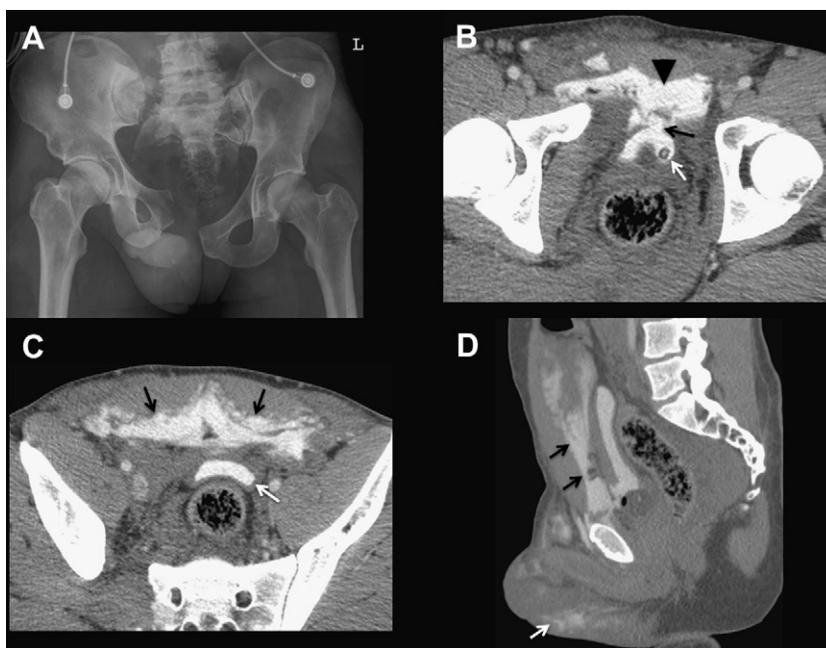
Extraperitoneal bladder rupture. (A) Frontal pelvic portable radiograph from a trauma series demonstrates a displaced vertical shear fracture with elevation of the right hemipelvis and marked diastasis at the pubic symphysis. (B) Axial CT cystogram image demonstrates extravasation of contrast from the anterior base of the bladder (*black arrow*). Contrast extends into the prevesicular space (*black arrowhead*). A Foley catheter is identified in the bladder lumen (*white arrow*). (C) Axial CT cystogram image more superior than in B demonstrates extraperitoneal contrast accumulation along the anterior pelvic wall (*black arrows*). Contrast material is identified in the bladder lumen (*white arrow*). (D) Sagittal CT scan demonstrates the extent of extraperitoneal contrast extravasation into the anterior abdominal/pelvic wall (*black arrows*). Contrast also extends inferiorly into the scrotum (*white arrow*), consistent with disruption of the urogenital diaphragm.
